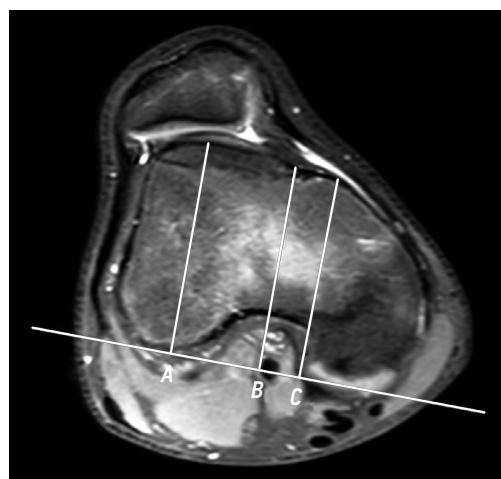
Trochlear groove depth measurement on magnetic resonance imaging in a 16-year-old female with patellar instability: A , maximal anteroposterior distance between the femoral condyles and lateral facet; B , maximal anteroposterior distance between the femoral condyles and deepest point of the trochlear groove; and C , maximal anteroposterior distance between the femoral condyles and medial facet.
